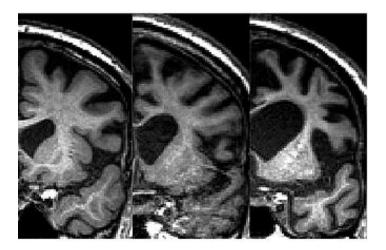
MRI evidence of escalating atrophy of prefrontal cortex in frontotemporal dementia
